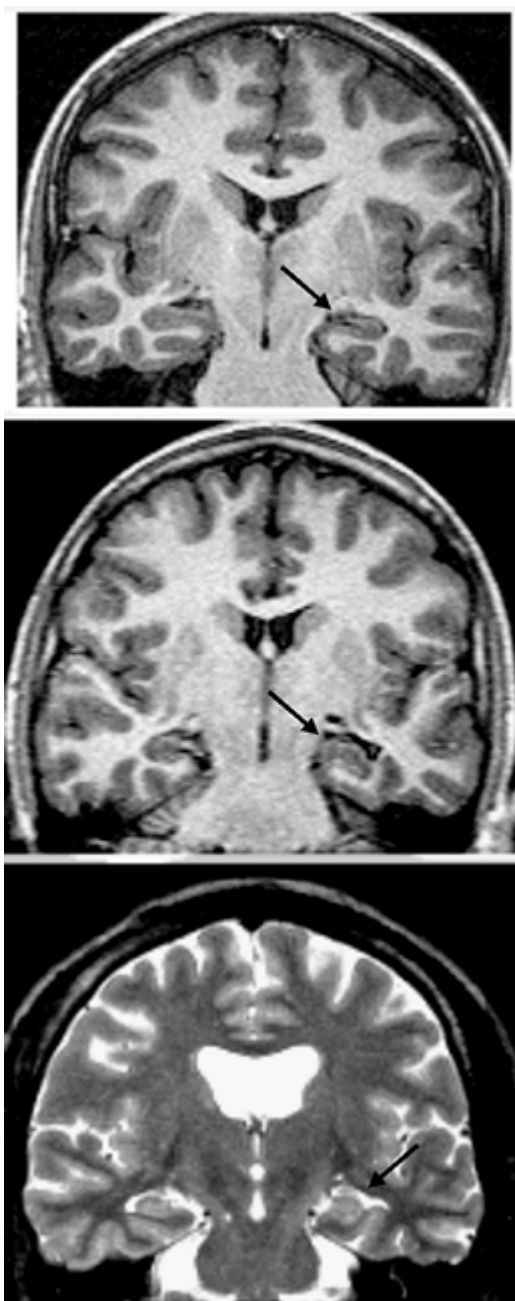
Hippocampal abnormalities in three asymptomatic individuals from families with mesial temporal lobe epilepsy. Top: Coronal T1-IR image of a 14-year-old boy, showing flattened and atrophic left hippocampus (*arrow*). Middle: Coronal T1-IR image from a 15-year-old boy. The left hippocampus is atrophic and bent clockwise and has an abnormal, “irregular” shape (*arrow*). Bottom: Coronal T2-FSE image from a 26-year-old man. The left atrophic hippocampus has an abnormal, “rounded” shape (*arrow*). In addition, the fusiform gyrus and collateral sulcus on the left have an abnormal shape. Note also the absence of septum pellucidum. (Reproduced, with permission, from Kobayashi E, Li LM, Lopes-Cendes I, et al. Magnetic resonance imaging evidence of hippocampal sclerosis in asymptomatic first-degree relatives of patients with familial mesial temporal lobe epilepsy. *Arch Neurol*. 2002;59(12):1891-1894. Copyright © 2002, American Medical Association. All rights reserved.)
